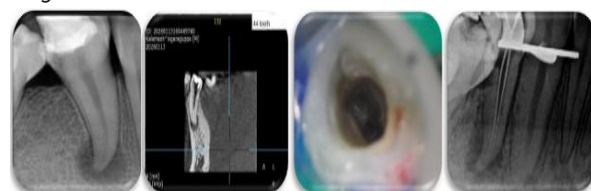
(a) Pre operative wrt 44 (b) Pre operative CBCT wrt 44 (c) Access opening (d) Working length
